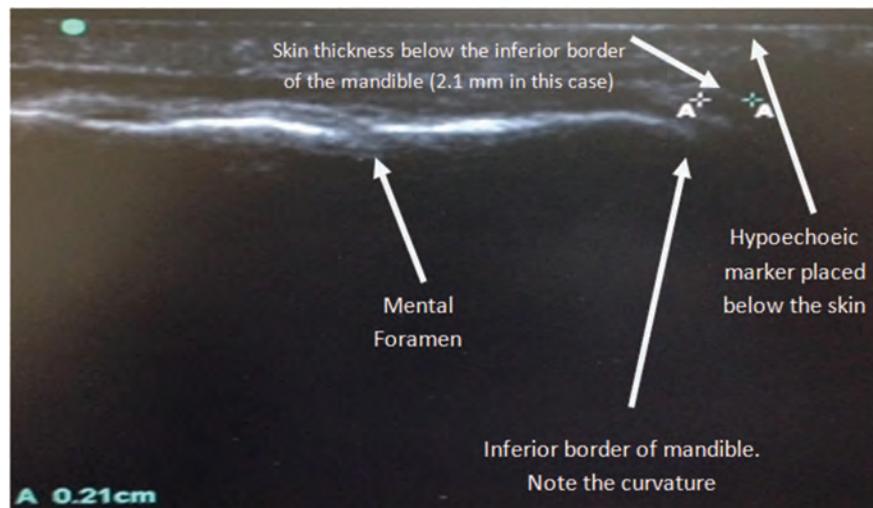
Ultrasound image showing the inferior border of the mandible and the mental foramen.
